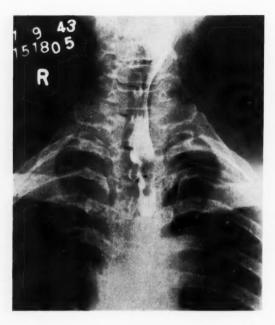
Roentgenogram, anterio-posterior view, showing the barium in the vallecula and the pyriform sinuses and the left side of the pharynx. The right side clears itself completely.
